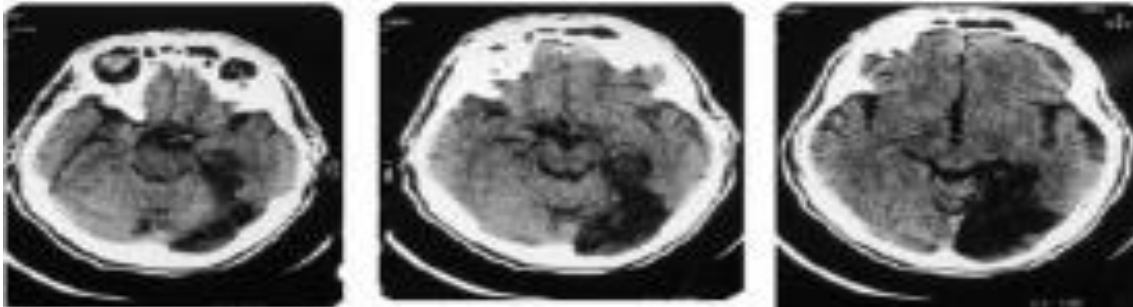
JFJ-CT Scan (3 months post-onset) showing a left hemisphere infarct, involving the occipital and the medial inferior temporal lobes, sparing the temporal pole. Source: Farrajota and Martins (2007).
